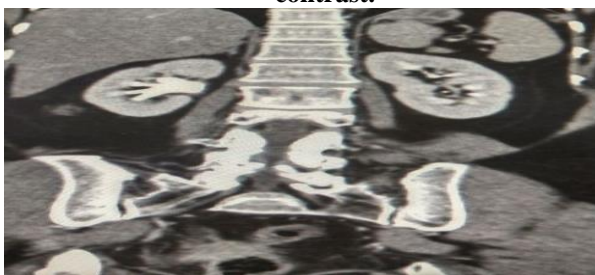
Coronal MIP Post-Contrast CT images showing normal Nephrographic phase and delineation of collecting system in this patient with hematuria by split bolus protocol.
